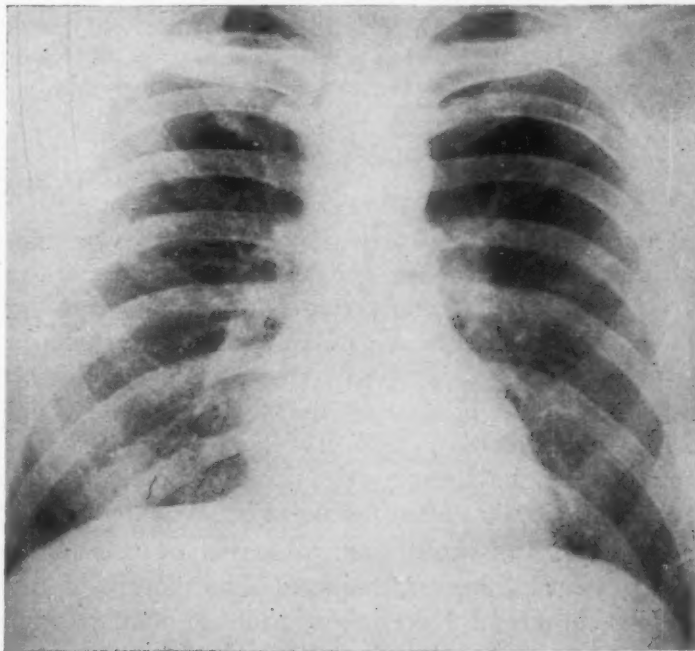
Chest roentgenogram taken five weeks after second hospital admission shows no abnormalities.
